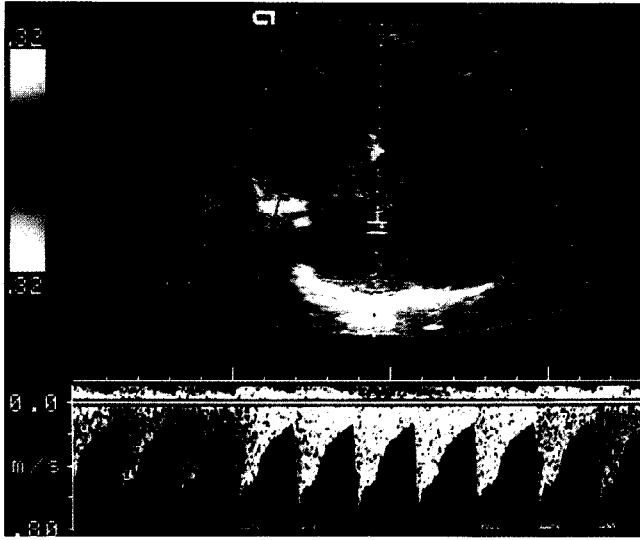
Transverse sonogram of the fetal head which shows how flow velocity waveforms of the middle cerebral artery are obtained
